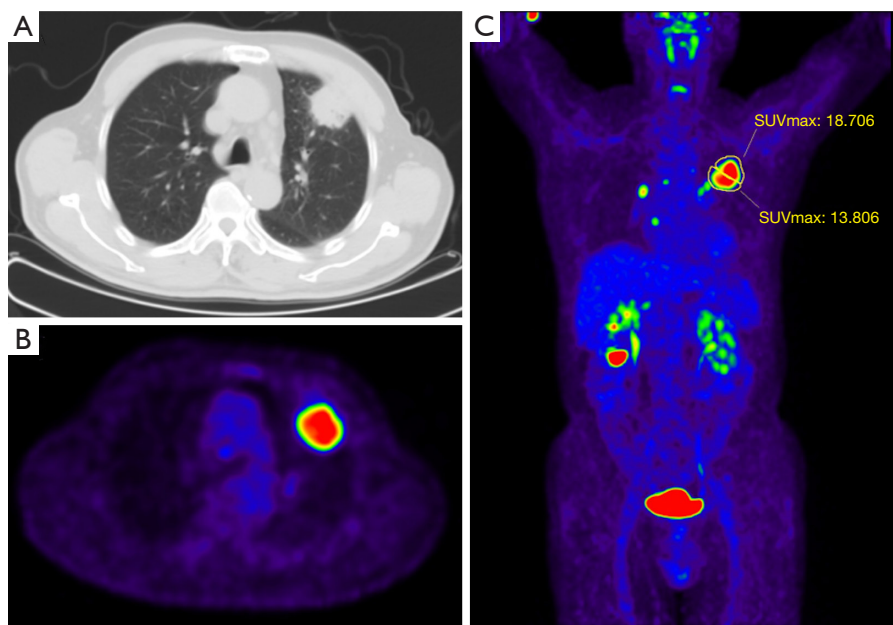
Images from a 73-year-old male patient with tuberculosis. Transaxial CT (A) showed a soft mass in the left upper lobe. The mass presented profound 2-¹⁸F]FDG uptake on transaxial PET image (B). The SUVmax values of the pSUVmax and dSUVmax regions were 13.806 and 18.706, respectively (C). The ratio of pSUVmax to dSUVmax was calculated as 0.738, which indicated a benign lesion. PET, positron emission tomography; SUVmax, maximum standard uptake value; pSUVmax, proximal SUVmax; dSUVmax, distal SUVmax.
